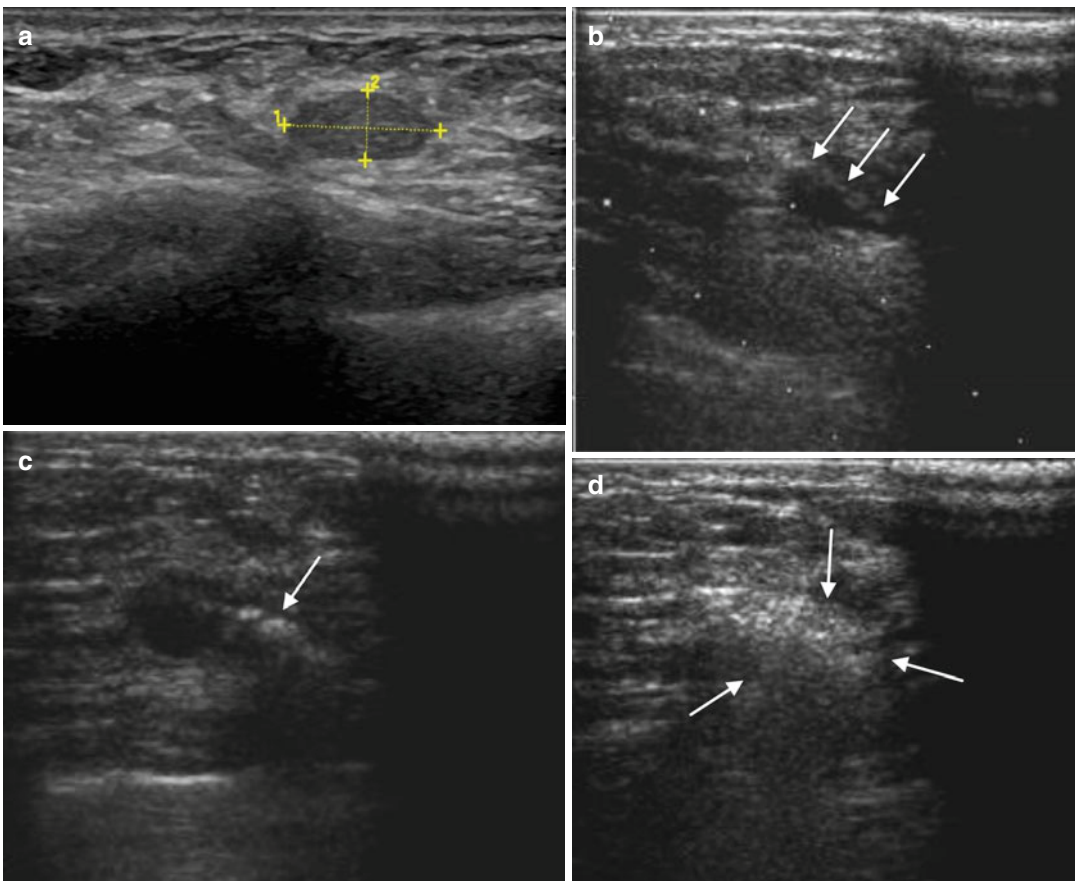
Images of a 43-year-old woman with left breast fibroadenoma treated by microwave ablation. (a) Sonogram shows a well-circumscribed oval-shaped solid mass with the size of $1.2 \times 0.6 \times 1.1$ cm. (b) Sonogram shows successful placement of the antenna (*arrow*). (c) Sonogram shows increased echogenicity of the mass near the irradiating segment of the antenna at the beginning of microwave ablation (*arrow*). (d) Sonogram shows
